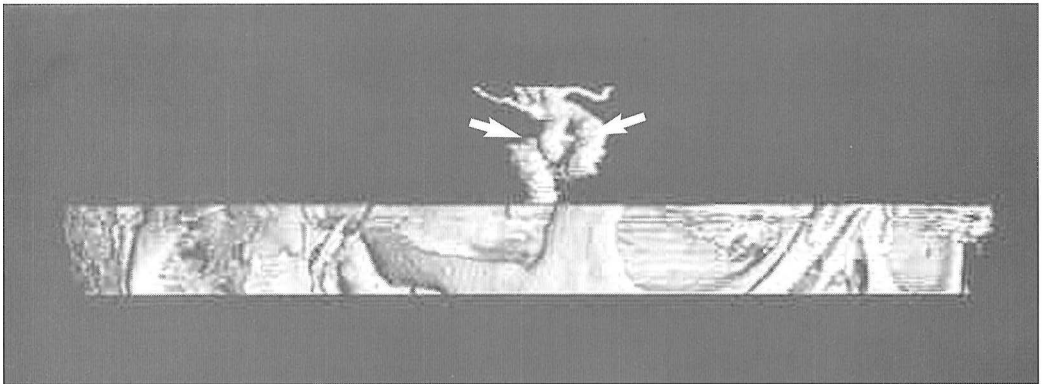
CT angiogram, volume rendering technique, right anterior oblique view, demonstrates a longish aneurysm coming out from the right internal carotid artery and spreading backwards and downwards in the area of the third nerve (arrows).
